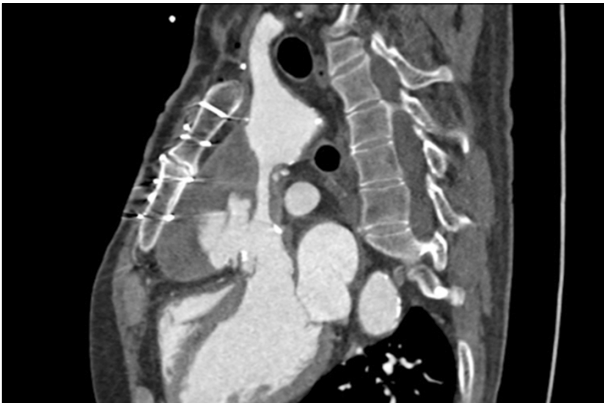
A preoperative enhanced computed tomography image shows a contained rupture of the ascending aorta with pseudoaneurysm formation.
